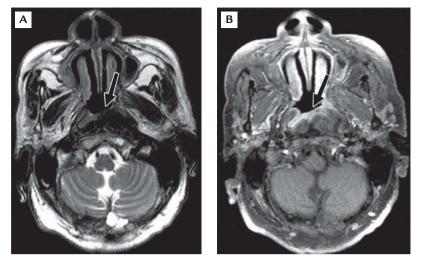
(A) Axial T2-weighted magnetic resonance imaging shows a hypointense, submucosal soft-tissue mass in the nasopharynx (arrow). (B) Axial gadolinium-enhanced T1-weighted magnetic resonance imaging shows heterogeneous enhancement of the lesion, mainly at the left aspect of the nasopharynx (arrow).
